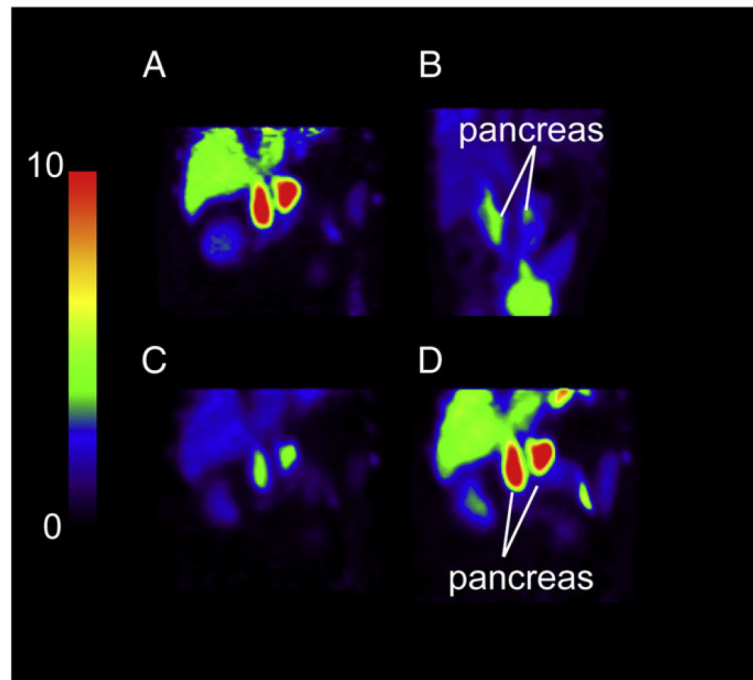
PET SUV images after injection of ^{18}F -FP-(+)-DTBZ (A, C, and D) and ^{18}F -FP-(-)-DTBZ (B). All images are displayed on the same SUV scale. A, C, D: PET images, summed from 120 to 150 min, from the same baboon (Baboon B) scanned with ^{18}F -FP-(+)-DTBZ under control condition (A) and following displacement by unlabeled FP-(+)-DTBZ (C) and fluvoxamine (D). B: PET images of ^{18}F -FP-(-)-DTBZ summed from 0 to 90 min (Baboon D).
